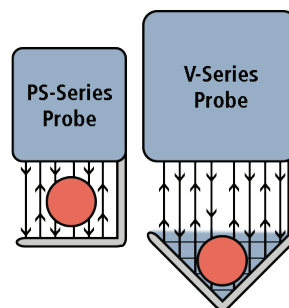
The full height of the PS-Series Probe's ultrasonic window has the same flow sensitivity, so that the vessel can be positioned any-where within the Probe. Only within the triangle (shaded) portion of the V will the V-Series Probe reach its full flow sensitivity.
